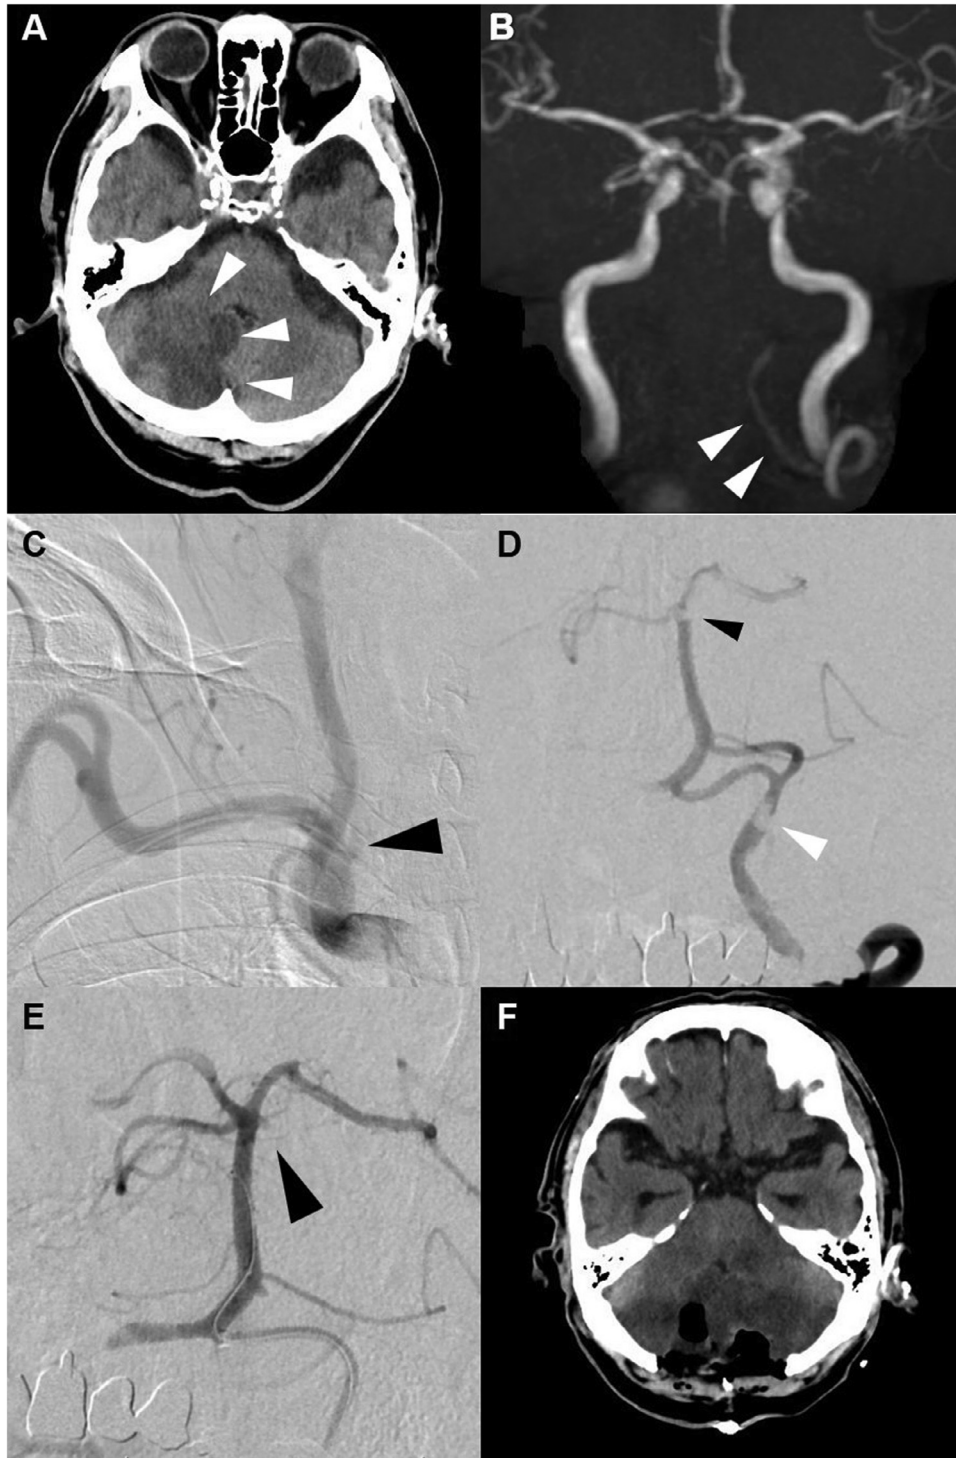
(A) Computed tomography (CT) scan showing a low-density lesion in the right cerebellar hemisphere (arrowheads). (B) Magnetic resonance angiography demonstrating occlusion of the right vertebral artery (VA) and the patent left VA (arrowheads). (C) Brachiocephalic angiography demonstrating the stump of the right VA (arrowhead). (D) Left vertebral injection showing contrast defects in the left VA (white arrowhead) and at the top of the basilar artery (BA) with occlusion of the left superior cerebellar artery (SCA) (black arrowhead). (E) Left vertebral injection immediately after thrombectomy showing recanalization of the top of the BA with persistent occlusion of the left SCA (arrowhead). (F) CT scan obtained after internal and external decompressive craniectomy demonstrating a large infarction core in the bilateral cerebellar hemispheres.
